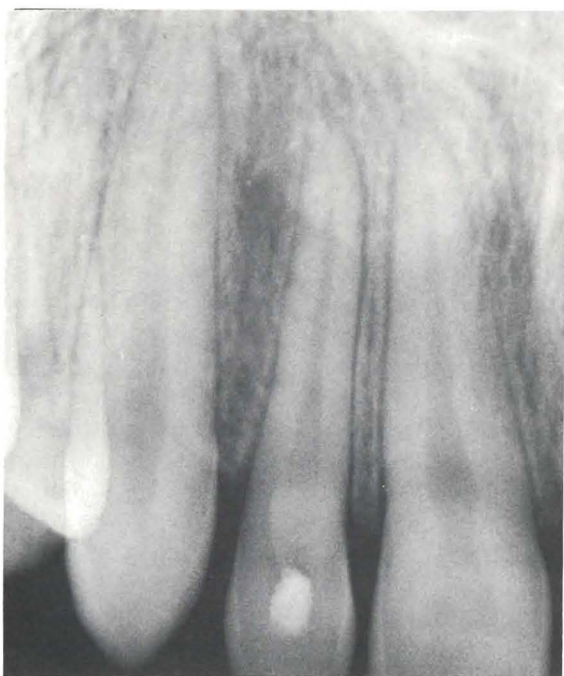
A radiograph taken immediately after replantation and application of a loosely packed, calcium hydroxide pulpal dressing. The tooth is in its proper position.
